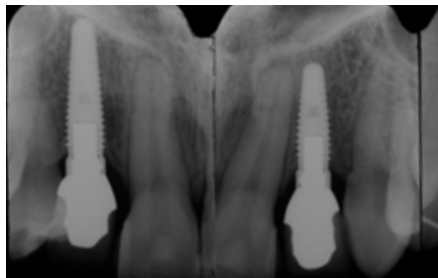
Final radiograph. The palatal splint between the two central incisors was eliminated and no protection devices were provided.
